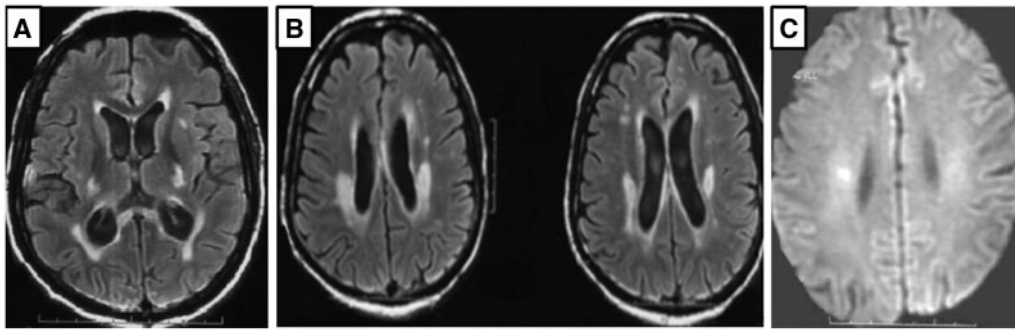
Cranial T2 FLAIR MRI axial sections show infarcts in the ischemic (A) and peri ventricular region bilaterally (internal border zone) (B) in a 45-year-old male, stage III TBM with type 2 diabetes mellitus and hypertension. CSW was diagnosed on Day 40, he developed infarction on Day 68 of admission. Hyponatremia was corrected after 12 days and urinary output normalized after 3 months. (C) Cranial DWI MRI axial section of another 15-year-old male, stage III TBM patient showing asymptomatic infarct in right peri-ventricular white matter (internal border zone) with CSW diagnosed at admission (Day 1).
